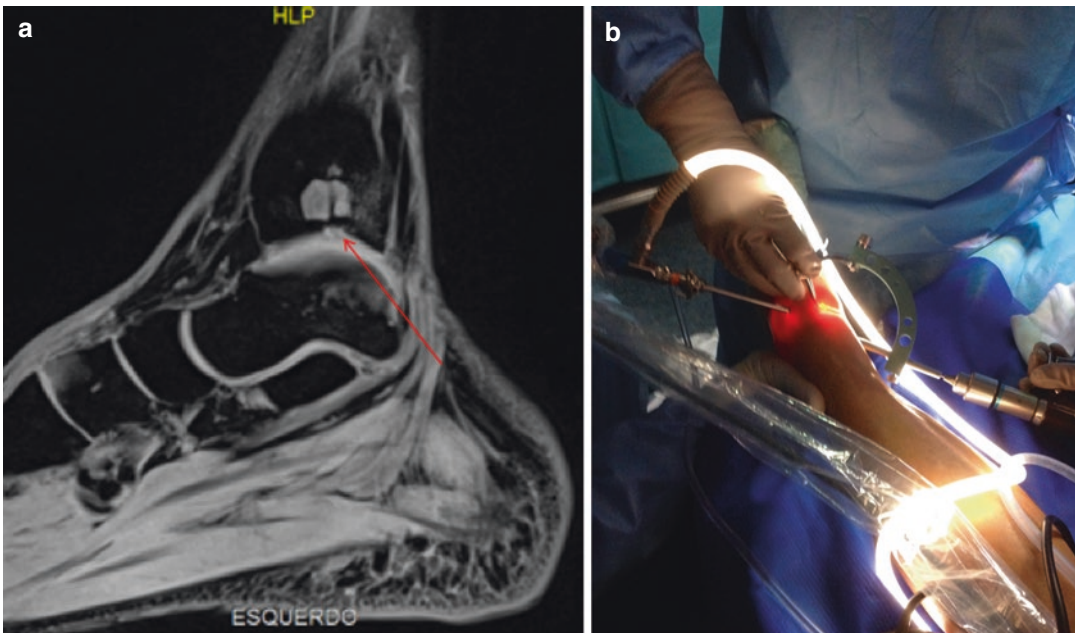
MRI image of tibial osteochondral defect (a). Retrograde drilling using specific aiming device (b)
